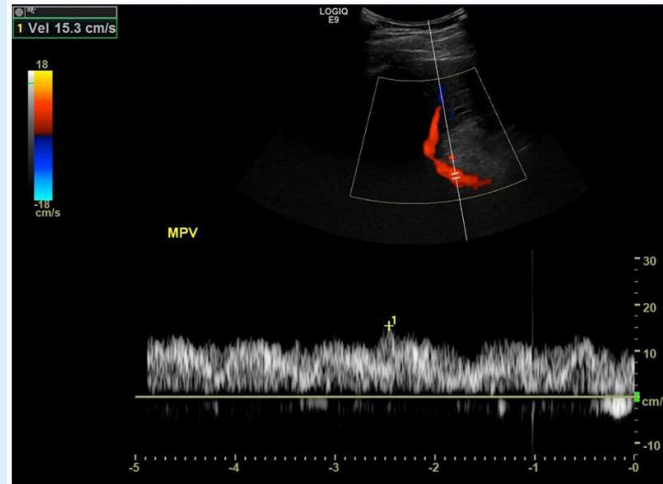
Normal spectral Doppler waveform of the main portal vein.
